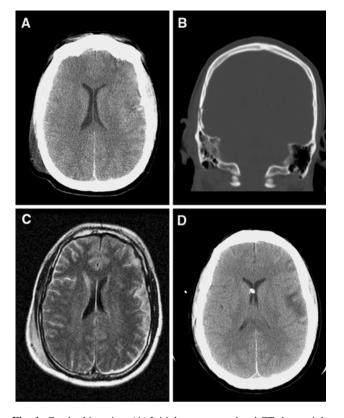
Cerebral imaging. (A) Initial noncontrast head CT shows right subgaleal hematoma with contracoup left frontal contusion with minimal cortical blood. (B) Initial reconstruction of head CT with bone windows shows right temporal/parietal fracture. (C) MRI (FLAIR) on day of presentation shows slight bilateral subarachnoid hyperintensity consistent with subarachnoid hemorrhage and left frontal cortical hyperintensity consistent with contusion and right parietal subdural hematoma. (D) Noncontrast CT, 13 days after injury, show hypodensity in the left frontotemporal insular region and normal ventricles with right ventriculostomy drain in place
